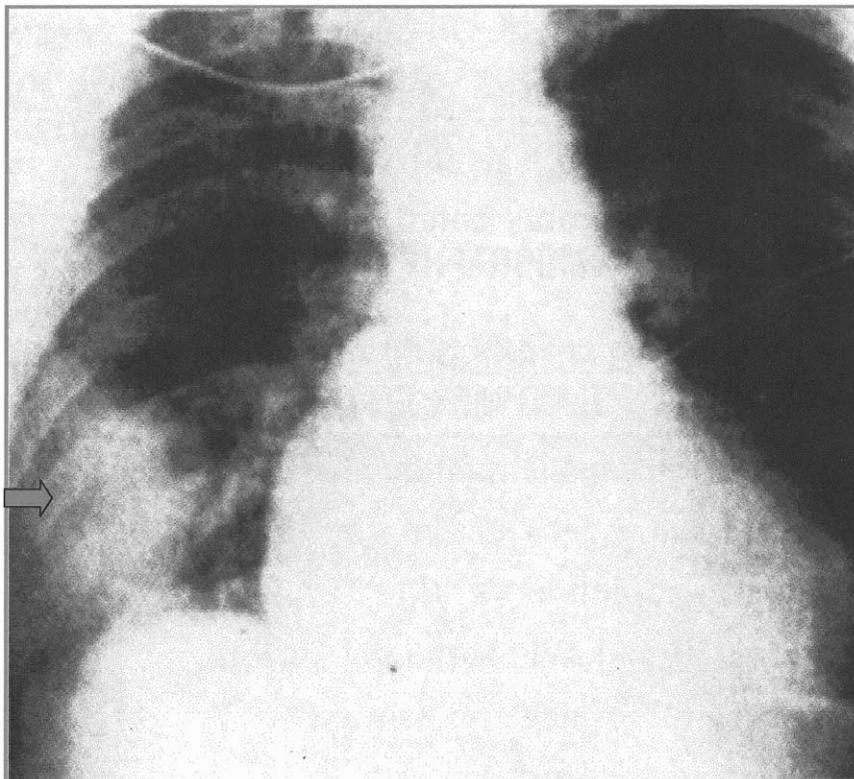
The Hampton hump (*arrow*), which is visible in some X-rays, is a classic finding caused by a pleural-based abnormality due to pulmonary infarction. Its presence is not common and should not be used to confirm or exclude pulmonary embolism.
